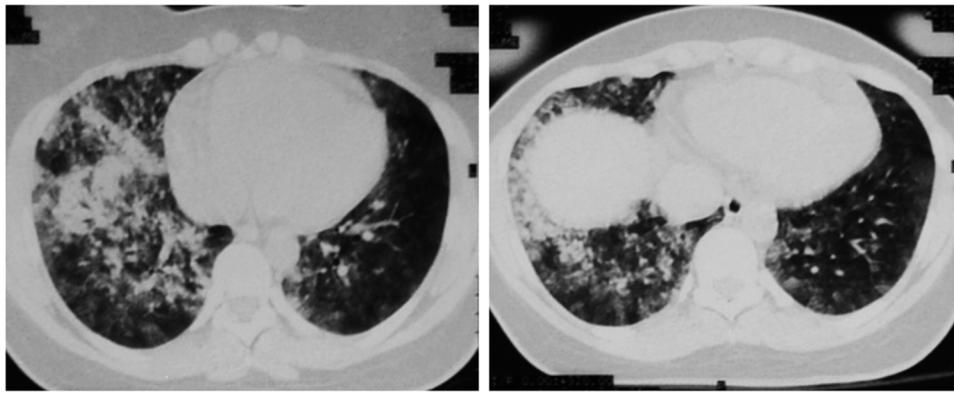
Typical patterns of HAPE identified at CT scan of a young woman after her arrival in La Paz, Bolivia at 3500 m. Note the patchy and bilateral presentation of edema, areas where oxygen transport to pulmonary capillaries is severely compromised, generating low V'/Q' areas responsible for the severe hypoxemia that can be encountered. The patient evolved favorably in 3 days and was able to fly back home on a scheduled flight, without sequelae.
